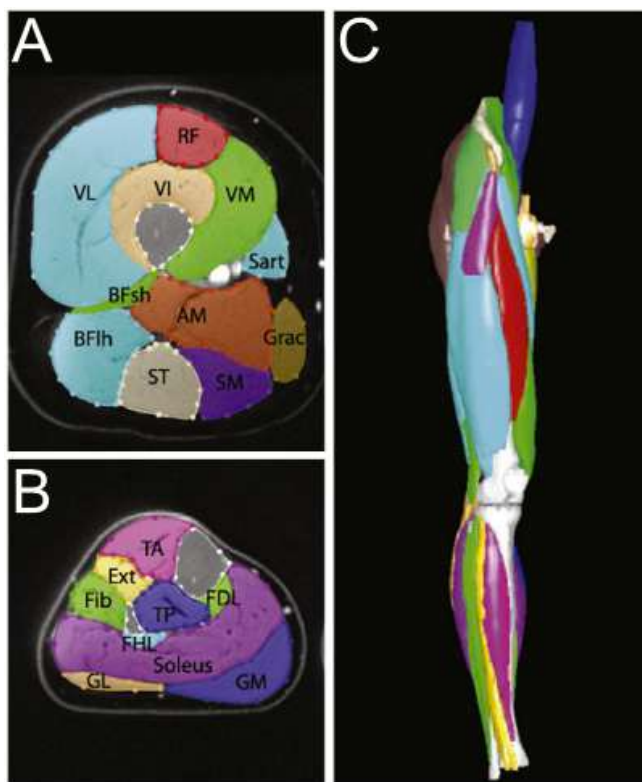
Three D-reconstruction of the leg from magnetic resonance imaging (MRI) scans. Muscles and bones were segmented in transversal images in each thigh cross-sections (A) and shank cross-sections (B). The reconstruction in 3D is shown in an anterior view (C). From Handsfield et al. (2014).
